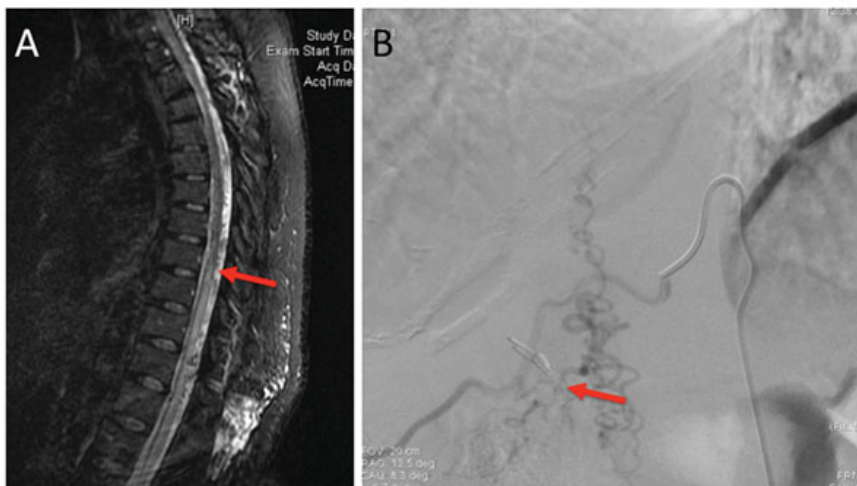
(A) Preoperative MRI STIR sequence demonstrates intramedullary T2 hyperintensity of the spinal cord and intradural extramedullary flow voids (arrow) along the dorsal aspect of the spinal cord. (B) Preoperative spinal angiogram, right T11 injection (AP view), demonstrates the dural arteriovenous fistula (arrow at fistula)
